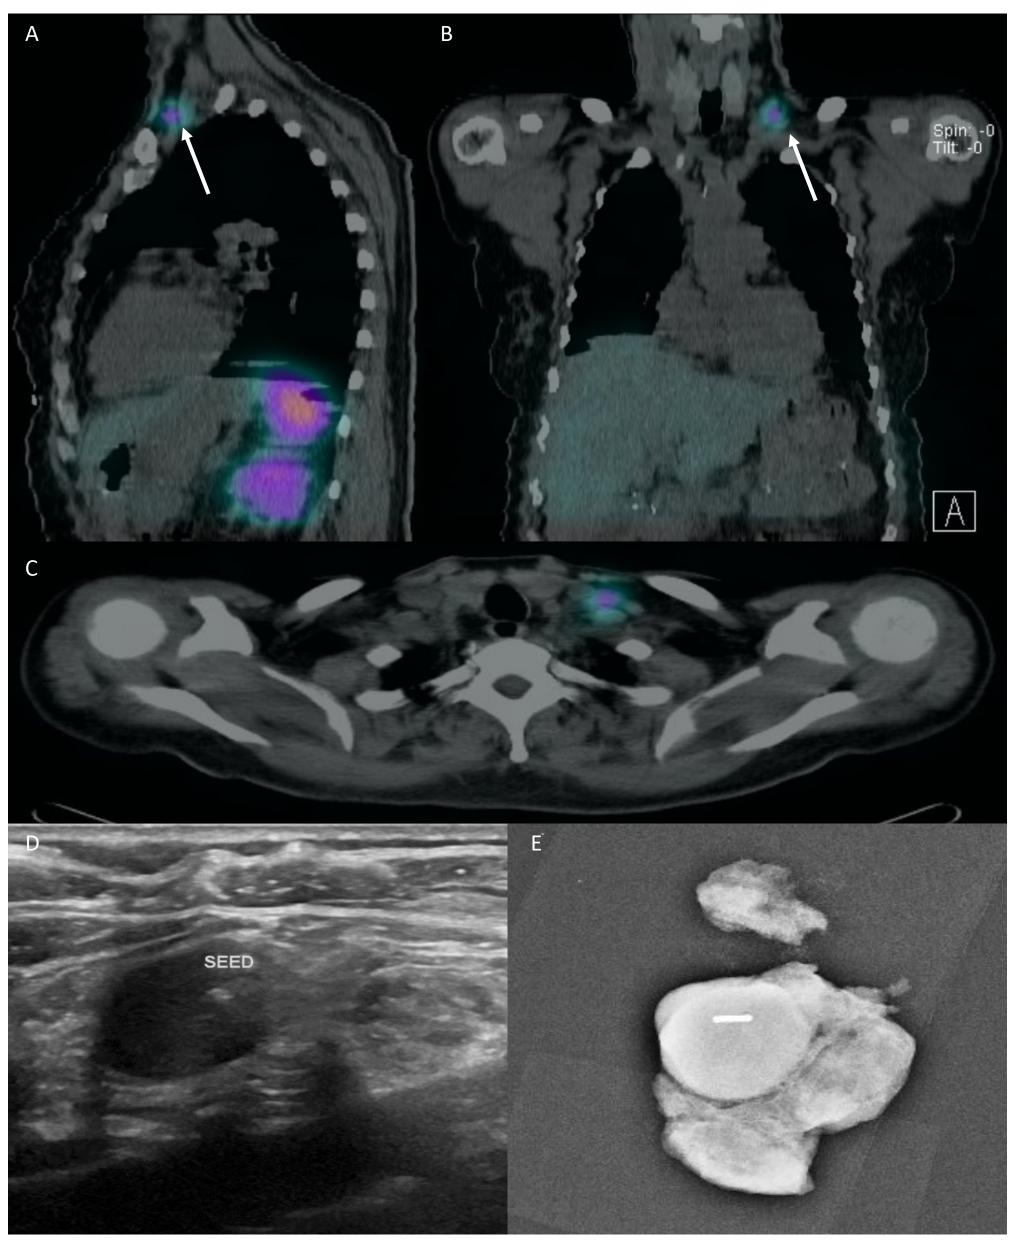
Neuroendocrine metastasis with cervical lymph node RSL. Surveillance nuclear somatostatin receptor study demonstrating increased radiotracer activity in the left neck suggesting metastatic disease (A-C). Ultrasound-guided radioactive seed placement (D). Post operative mammography of resected lymph node with radioactive seed (E).
